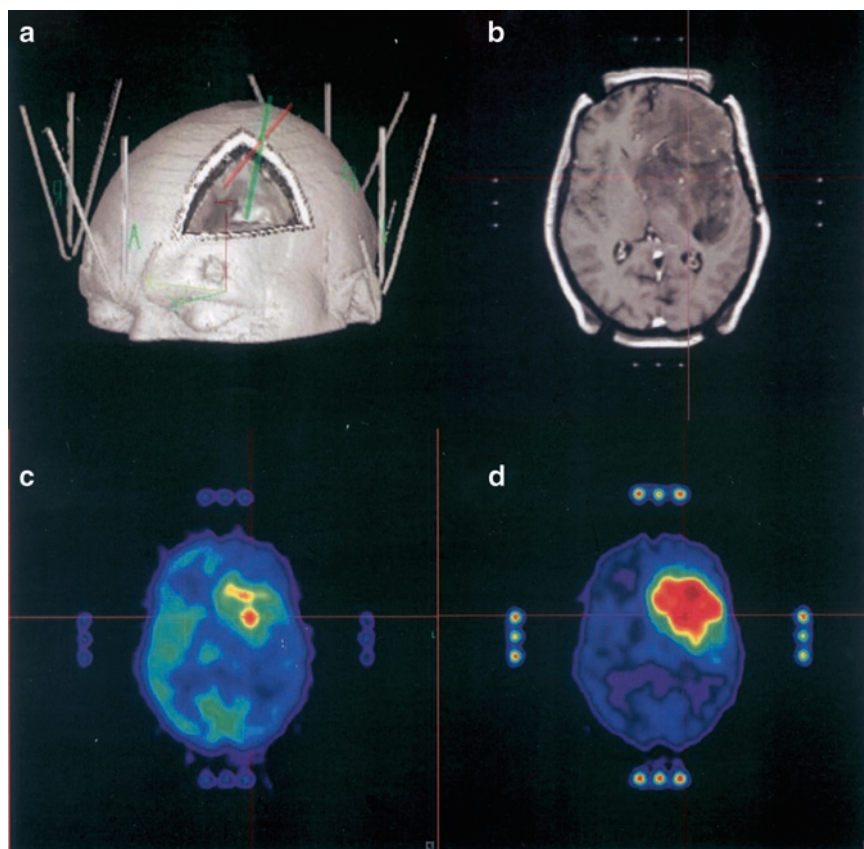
Stereotactic acquisition of MRI (a and b), FDG-PET (c) and Met-PET (d) images in an anaplastic oligoastrocytoma located in the right frontal area. The 3D surface reconstruction (a) shows the fiducials embedded into the localizers grooves which are filled up with radioactive  $^{18}\text{F}$ -fluoride sodium for allowing visualization on PET images (c and d). The extent of MET uptake was much larger than the extent of FDG uptake. There was a correspondence between the areas of highest tracer uptake on both PETs (c and d)
